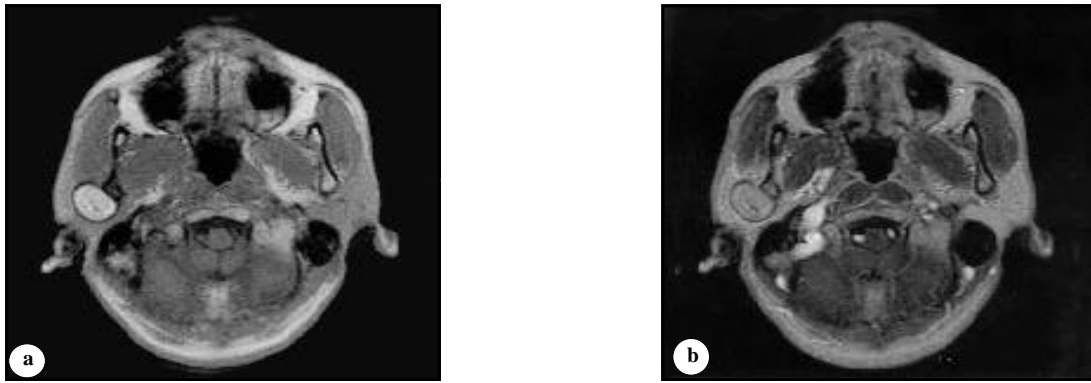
Magnetic resonance imaging demonstrating a) T1 and b) T2 with high signal intensity mass in the lateral part of the joint.
